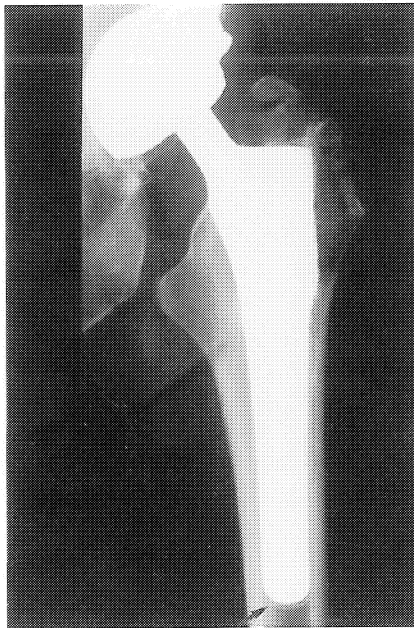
Typical acetabular and femoral radiodense lines (arrows) on anteroposterior (a) and lateral (b) radiographs.
